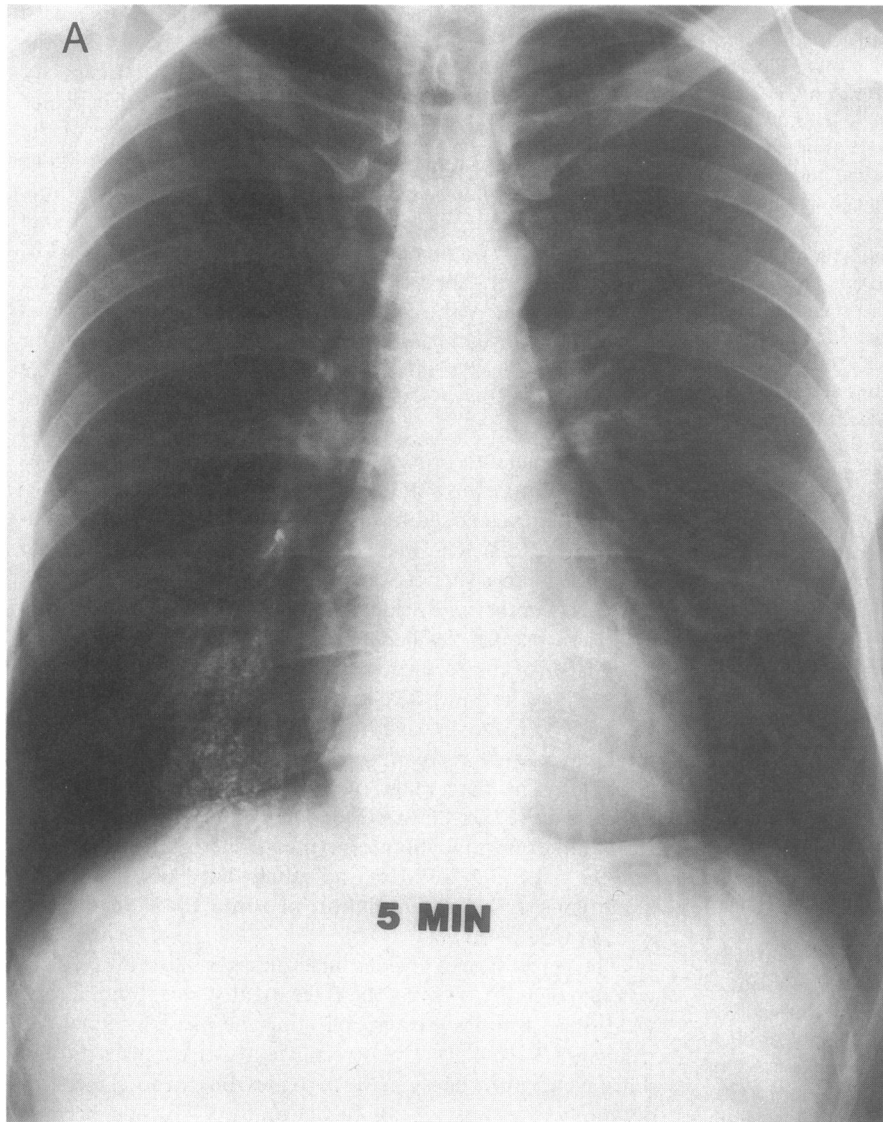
Posteroanterior (A) and lateral (B) chest radiographs taken 5 min (A, B) after the instillation of 10 ml of 10% BaSO₄ in a subsegment of the right middle lobe of a normal volunteer, using the identical technique used to instill LTB₄. The BaSO₄ is visible in an alveolar pattern in an anterior subsegment of the right middle lobe. Repeat films taken 4 h later showed no appreciable change in the radiographic distribution of the BaSO₄.
